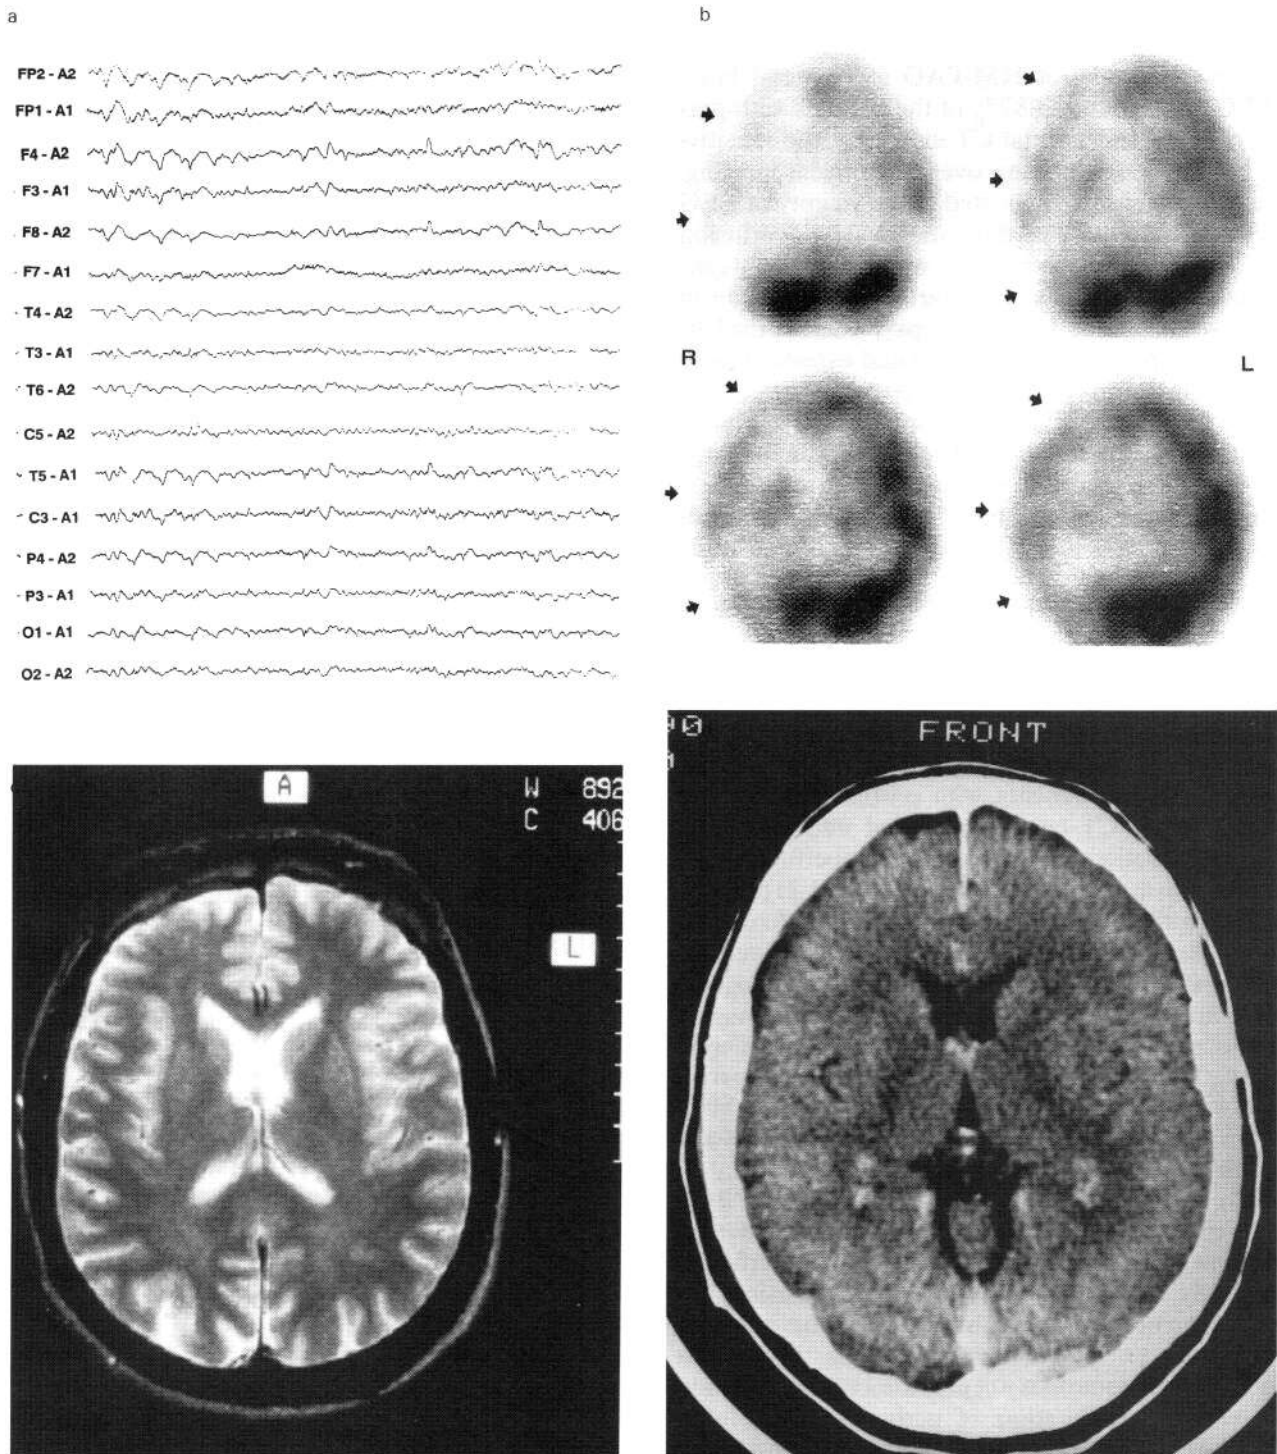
a) A 45-year-old male with medically intractable complex partial seizures for 13 years had a progressing right temporal irritative focus on EEG. b) The SPECT scanning revealed a marked and wide-spread hypoperfusion in the right hemisphere in two consecutive scans two months apart. c) The follow-up with CT and d) MRI were normal. Despite of adequate antiepileptic medication the patient had daily fits.
